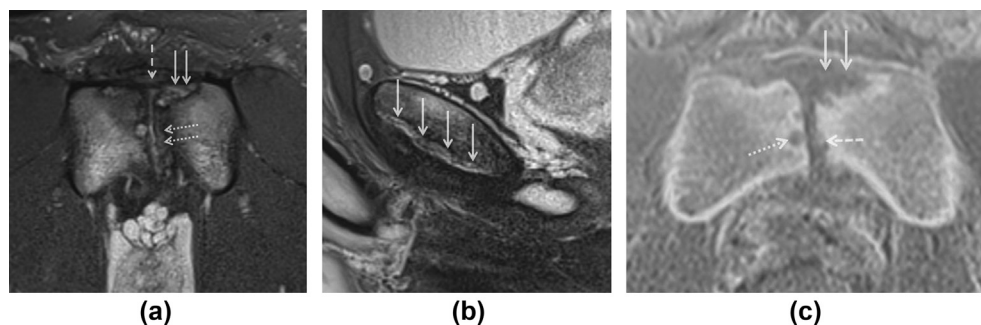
A 24-year-old elite AFL player with bilateral, left greater than right, groin pain. (a) Axial T2-weighted fat-saturated MRI showing a high signal superior left pubic apophysis (arrows) at the medial adductor longus origin, compatible with superior pubic apophysitis. The more dorsal left apophysis (dotted arrows) is “open”, resulting in a widened appearance of the symphysis, but is normal in signal. Note the normal anterior pubic ligament (dashed arrow). Small right high-signal cyst-like structure (arrowhead), iso-intense to the left apophysitis, is compatible with either an oedematous displaced cartilage rest or an area of apophysiolysis. (b) Left groin parasagittal T2-weighted fat-saturated MRI showing extensive intermediate signal apophysis due to delayed maturation of the entire ventral rampart on the most symptomatic groin (arrows). (c) Axial VIBE MRI at the same level as Fig 5a showing delayed maturation of the anterior left pubic apophysis as well as the more posterior apophysis (arrows). Apophysiolysis is resolved as ill-defined intermediate–high subchondral signal, appearing as erosions (dashed arrow). Small “cyst”-like structure (dotted arrow), also in Fig 5a, is of similar signal intensity to apophysitis rather than fluid signal, and does not communicate with the thin central symphyseal cleft.
